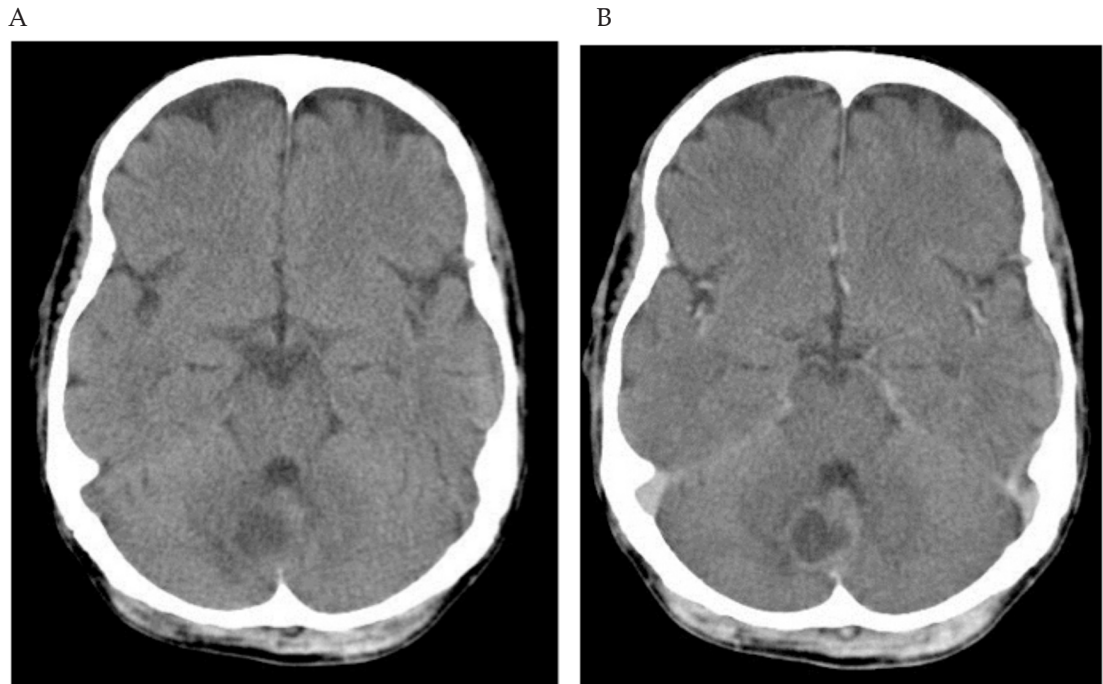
Cranial computed tomogram showing a 2-cm abscess in the cerebellar vermis. A. Precontrast film; B. Postcontrast film.
